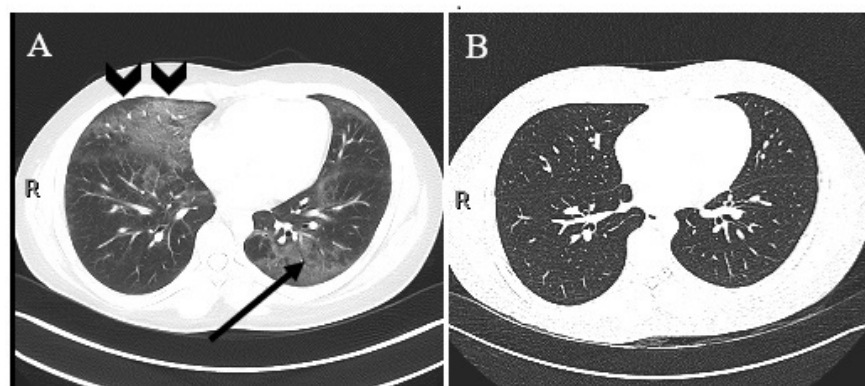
Chest Computed Tomography (CT) of a patient hospitalized with EVALI
